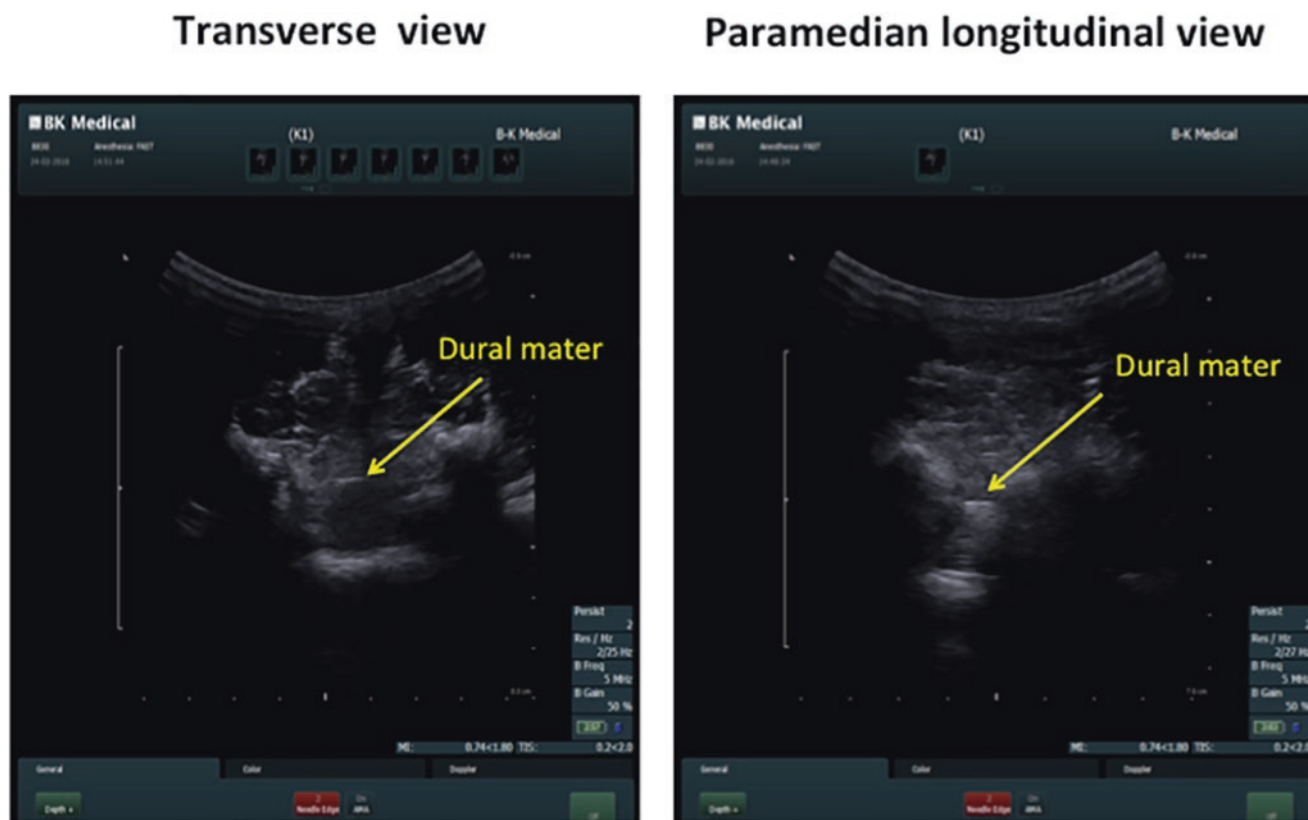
Transverse and paramedian longitudinal ultrasound images at lumbar region
